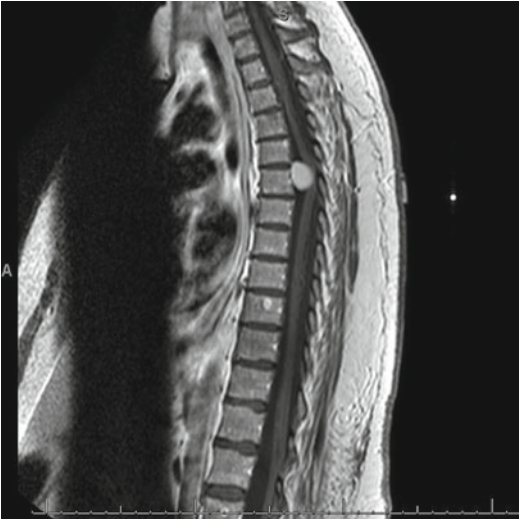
T1-weighted MRI with contrast enhancement depicting a meningioma
